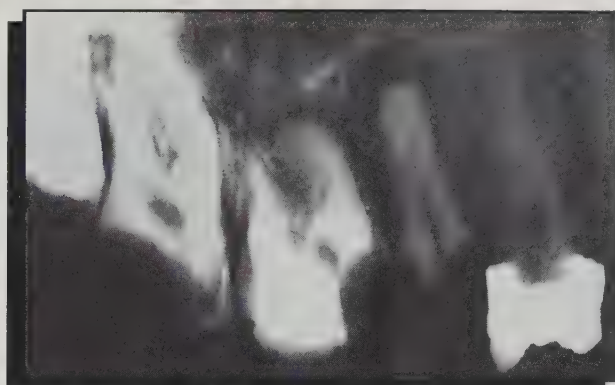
A digitized image of the radiograph depicted in Fig. 1, but with density and contrast comparable to the original radiograph.
